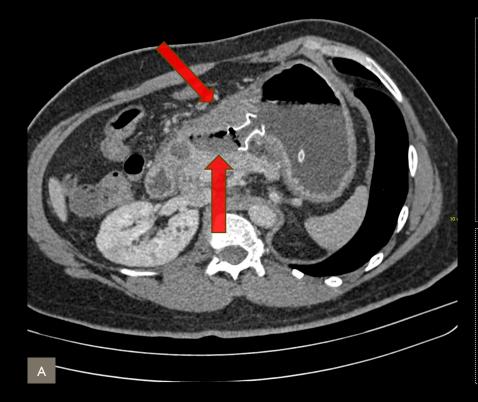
Computed tomography (CT) of the abdomen after the procedure, demonstrating hyperdense material located at the lesser curvature. In the region close to the lesser curvature of the stomach, a collection was observed (arrows)
